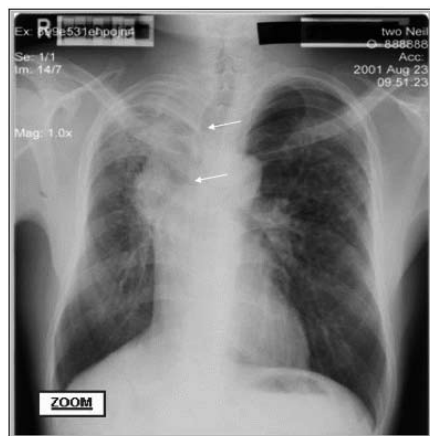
Chest radiograph showing old pulmonary tuberculosis superimposed on silicosis. (Features: Typical upper- and mid-zone nodulation of silicosis seen in left lung. Contraction fibrosis of right upper lobe attributable to previous tuberculosis, partly obscuring silicotic nodulation.)
